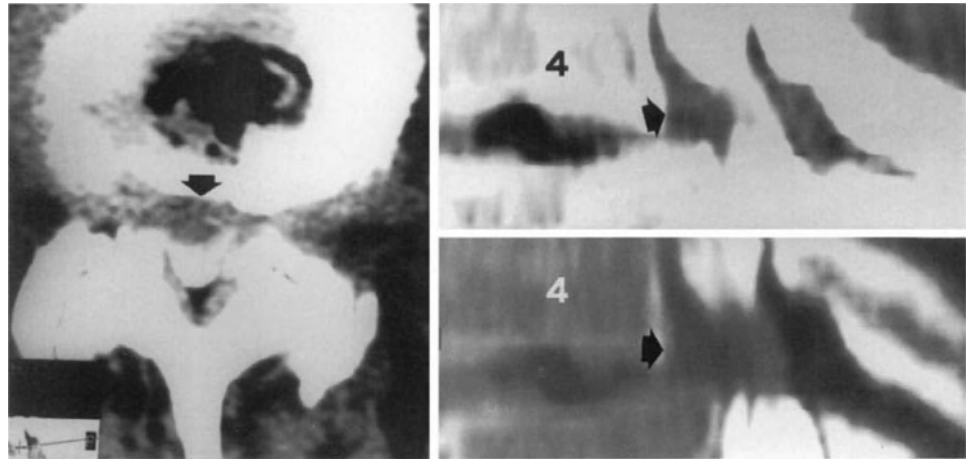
L4-L5 disc herniation in a patient with stenosis at this level and degenerative spondylolisthesis of L4. Myelo-CT scans show short transverse dimensions of the thecal sac due to stenosis of the spinal canal and a herniated disc (arrows) compressing the thecal sac anteriorly.
